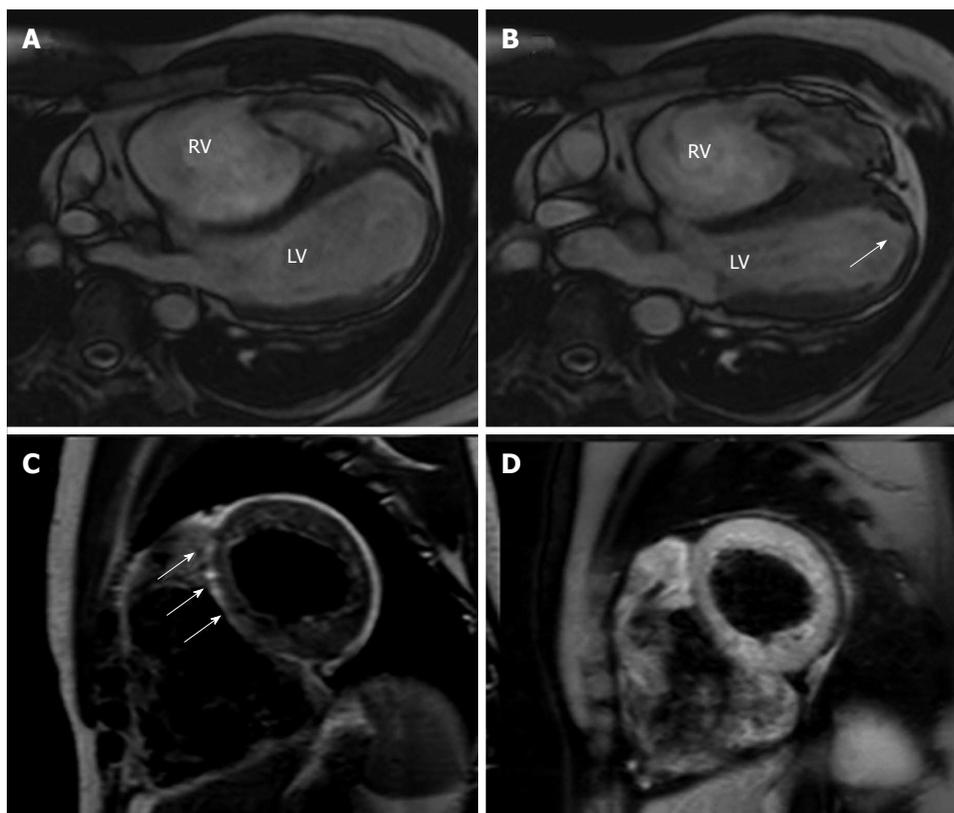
Cardiac magnetic resonance images of an arrhythmogenic right ventricular cardiomyopathy patient with mild left ventricular involvement. A, B: End-diastolic and end-systolic frames, off-axis 4 chamber view. Note the multiple bulging segments at right ventricular (RV) free wall. An apical hypokinesia of the left ventricle (LV) is also seen (arrow); C, D: Short axis T1-weighted dark blood imaging without (C) and with fat saturation (D) in the same patient with arrhythmogenic right ventricular cardiomyopathy. Note the hyperintense area in the interventricular (IV) septum in T1-weighted image (arrows) and corresponding hypointensity at T1-weighted dark blood imaging with fat-saturation indicating fatty infiltration in the IV septum.
